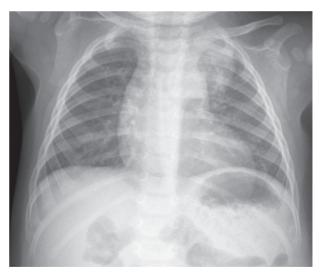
Chest radiography image revealing a well-defined hypotransparency in the left upper lobe (limiting arrows).
